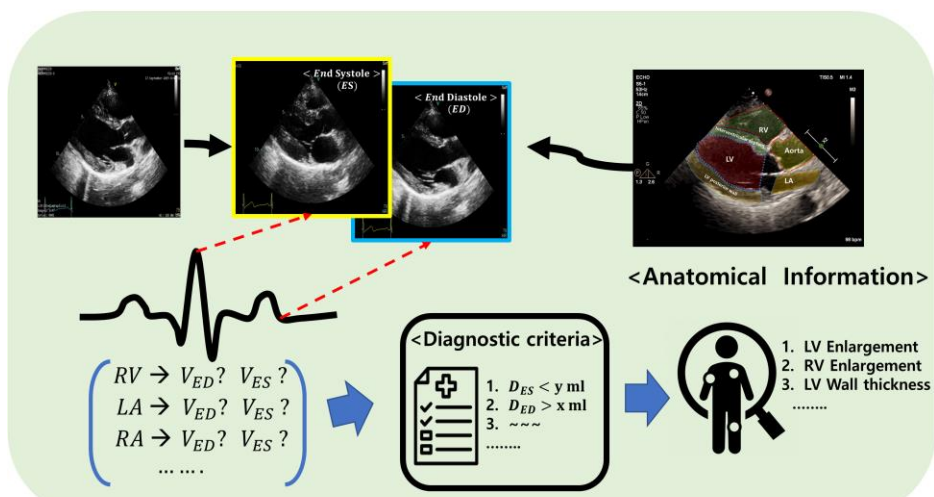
Clinical process of reaching echocardiographic diagnosis
